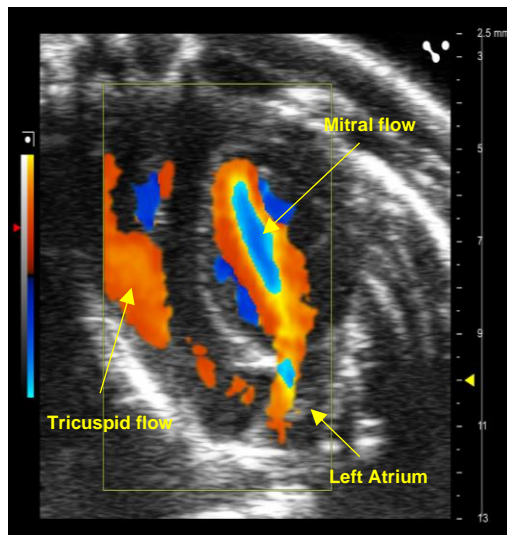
Apical 4 chamber view with Color Doppler of mitral blood flow (and tricuspid flow)
